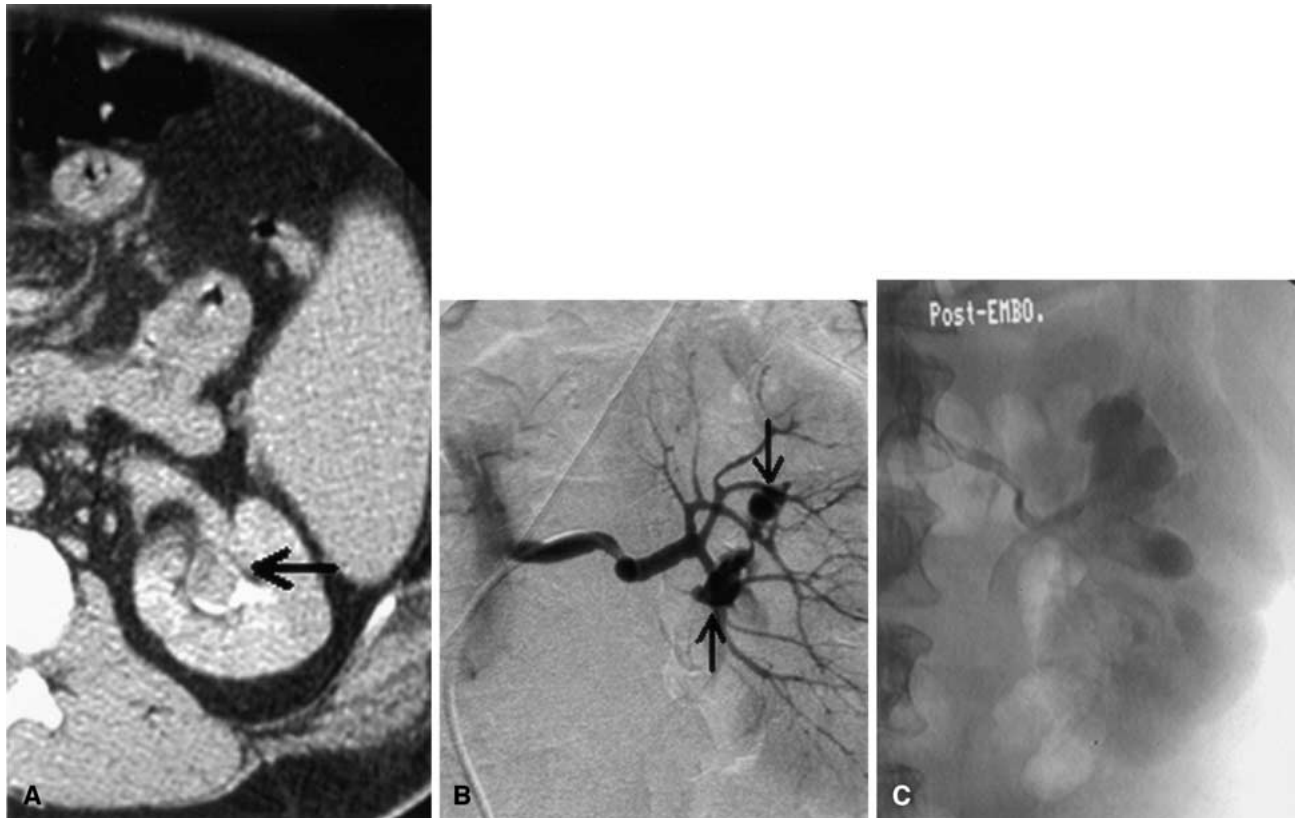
A 48-year-old man who suffered a motor-vehicle accident. A Delayed images from the contrast-enhanced axial CT scan demonstrate a filling defect (arrow) in the left renal collecting system suggestive of blood clot. B Selective left renal artery injection exhibiting communication between
